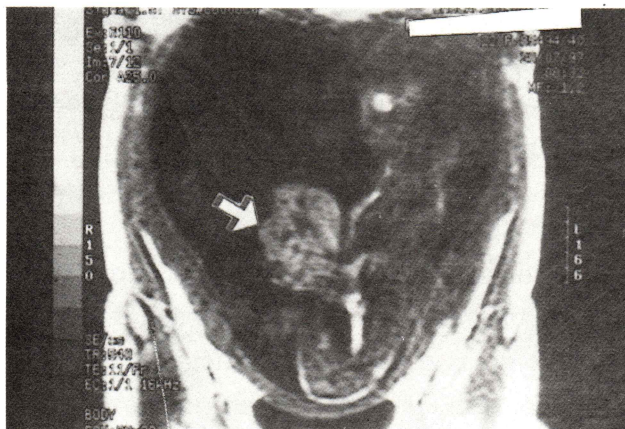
MRI image of omphalocele.
